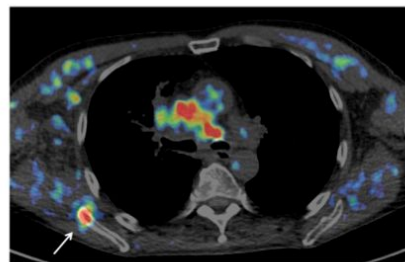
¹⁸F-Misonidazole positron emission tomography (PET) image fused with the corresponding CT displayed on a tumour-to-blood ratio (TBR) colour scale. Red regions depict a TBR >1.4, indicating hypoxia, and no visible PET depicts a TBR <1, indicating normoxia.³ This axial image shows the unexpected hypoxic bone metastasis indicated by the white arrow in addition to hypoxic nodal disease in the mediastinum.
